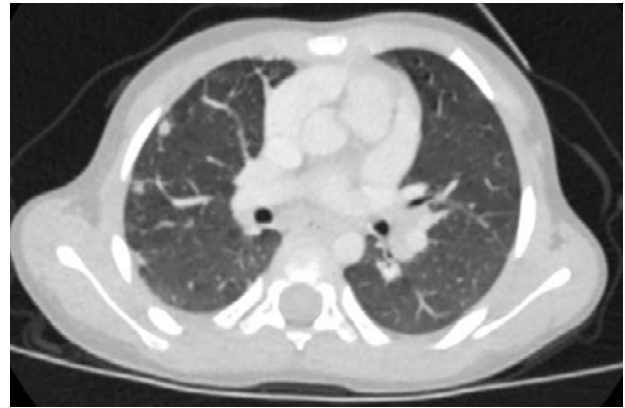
Lung nodules in parenchyma sections on thorax CT
